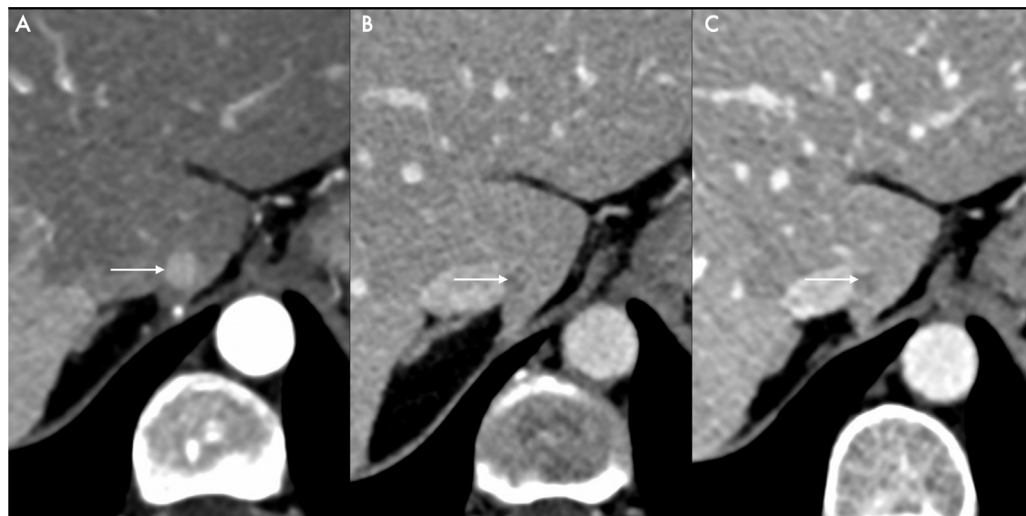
(A–C) LR-4 observation: Contrast-enhanced computed tomography study shows a 9 mm observation (white arrow) showing nonrim arterial phase hyperenhancement in late arterial phase (A), with nonperipheral washout in portal venous phase (B) and delayed phase (C) without any enhancing capsule in delayed phase (C).
